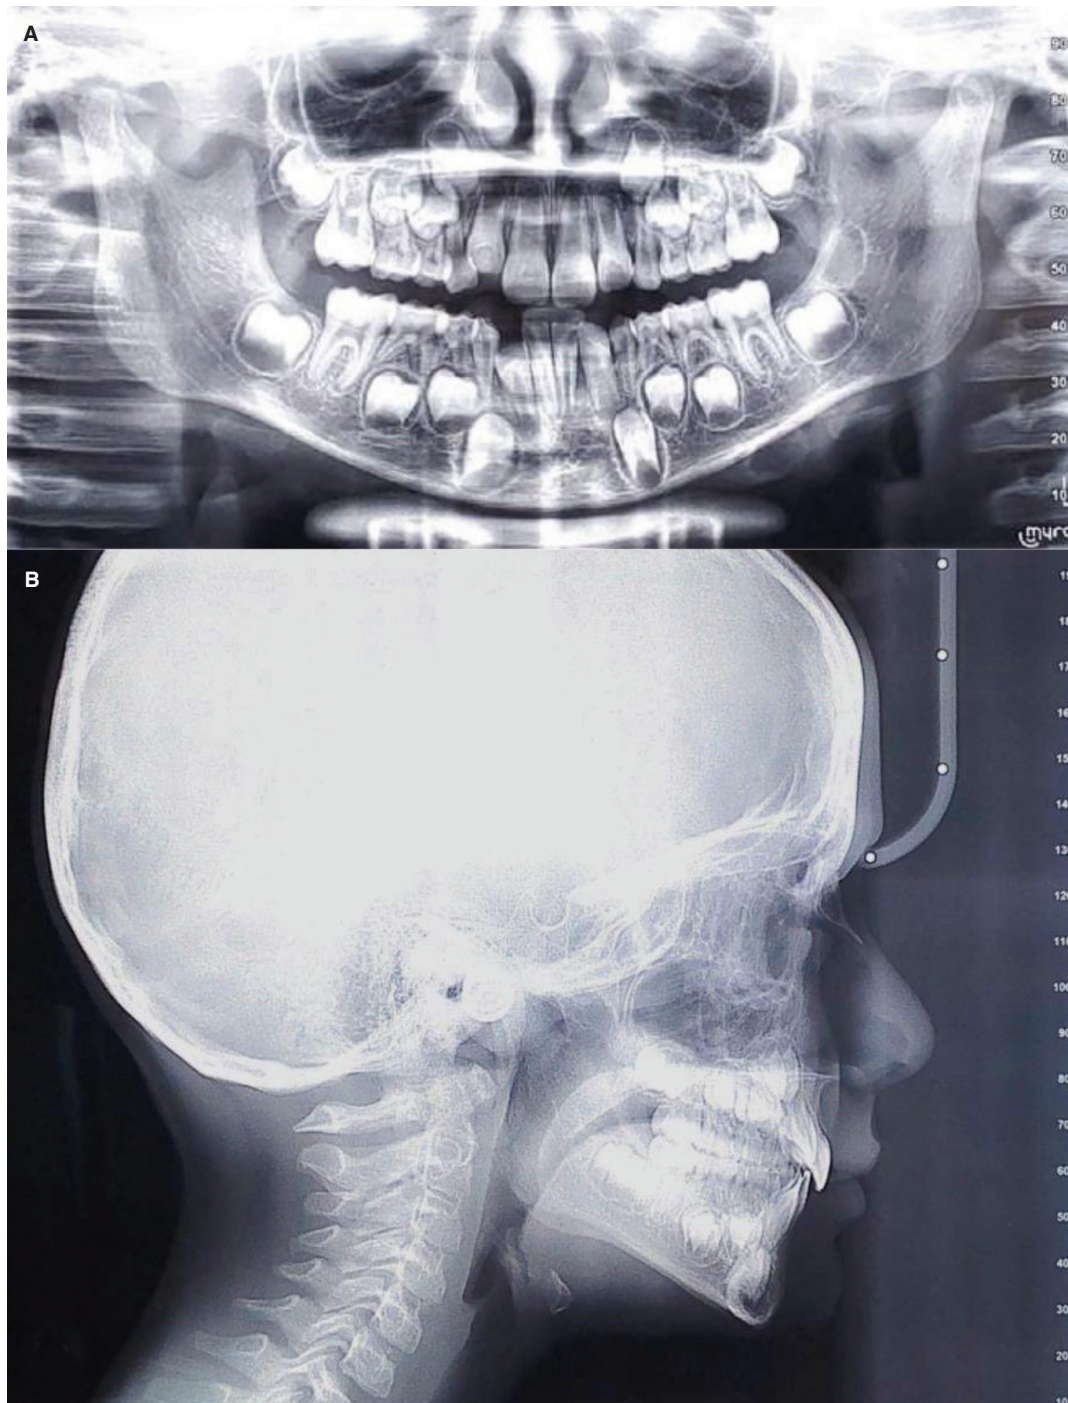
Panoramic radiography (A) and lateral cephalometric radiography (B) before the treatment.
